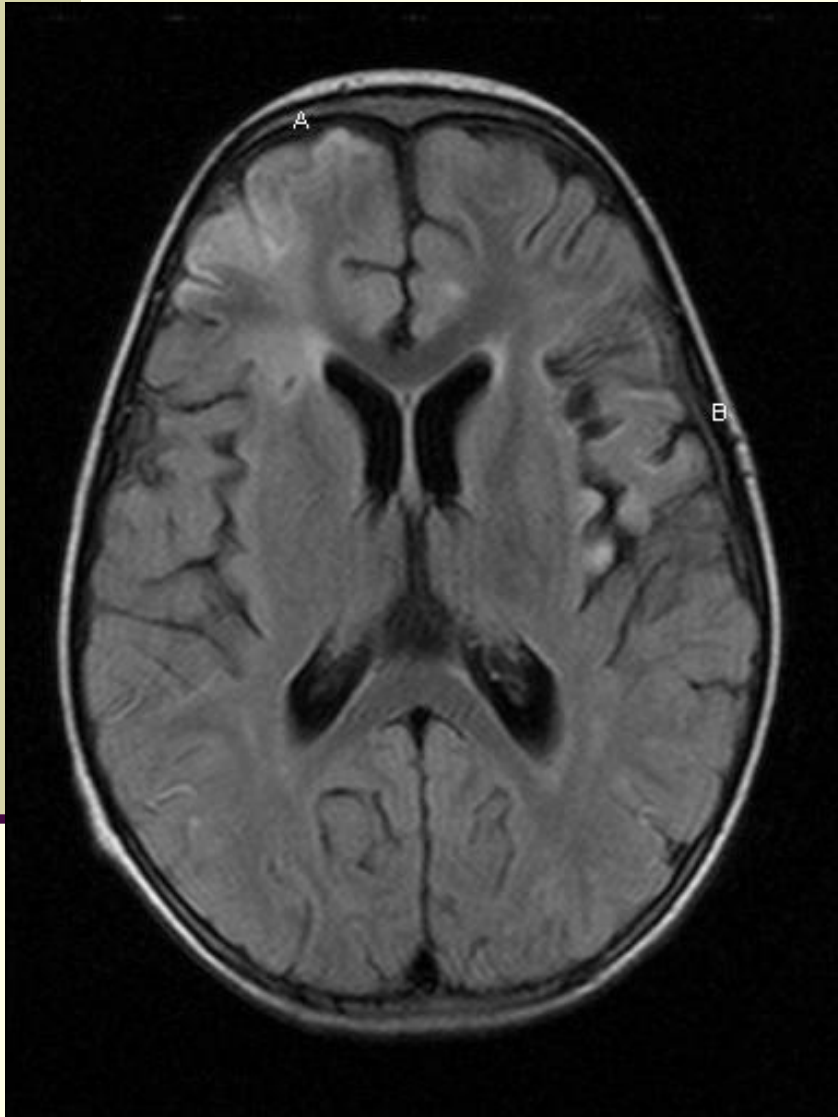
Axial T2 FLAIR images demonstrating: A (Patient 6) – bilateral temporal-parietal cortical hyperintensities; B (Patient 2) – parieto-occipital cortical hyperintensities; C (Patient 3) – superficial cortical (left frontal and bilateral occipital) and deep grey matter (bilateral head of caudate) hyperintense signal abnormalities; and D (Patient 8) – hyperintense signal changes in the right occipital cortex.*
